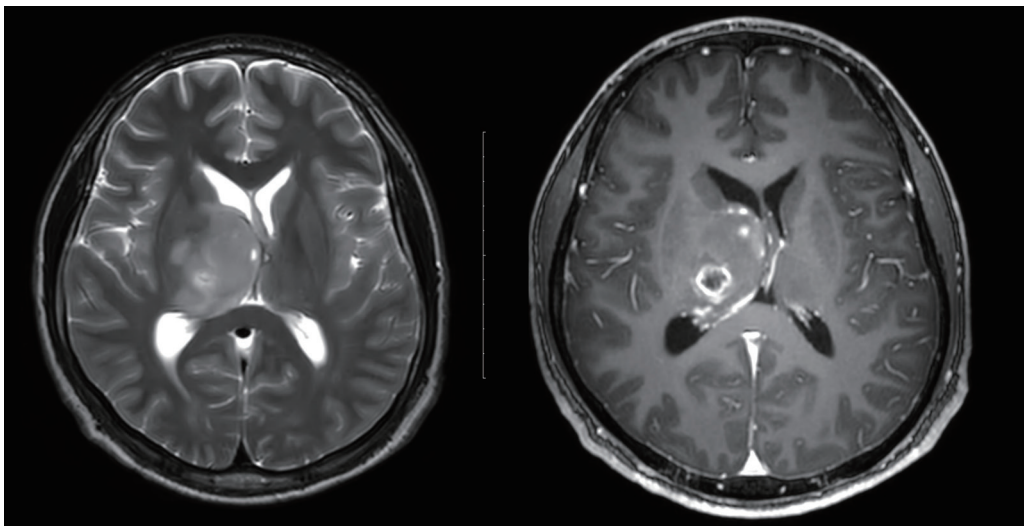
Magnetic resonance imaging findings in an 18-year-old male patient with neurofibromatosis type 1, diagnosed with high-grade glioma. Axial T2-weighted image (left) shows a hyperintense lesion involving the right corona radiata and thalamus. Contrast-enhanced T1-weighted image (right) reveals cystic changes with peripheral enhancement. The patient was diagnosed with high-grade glioma based on stereotactic biopsy.
